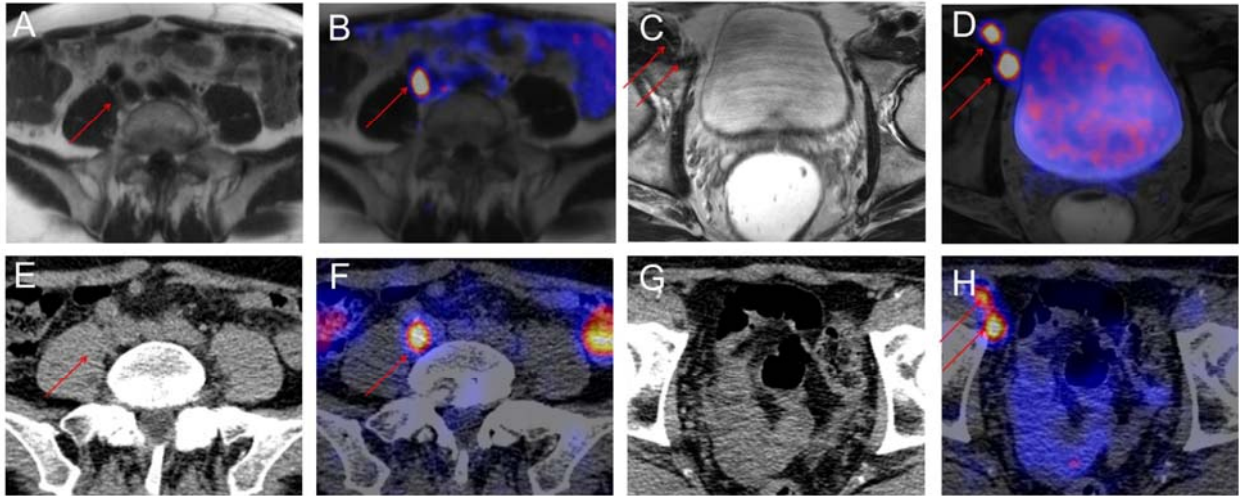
Preoperative ⁶⁸Ga-HBED-CC PSMA PET/MR (A-D) and ^{99m}Tc-PSMA-I&S SPECT/CT (E-H)
